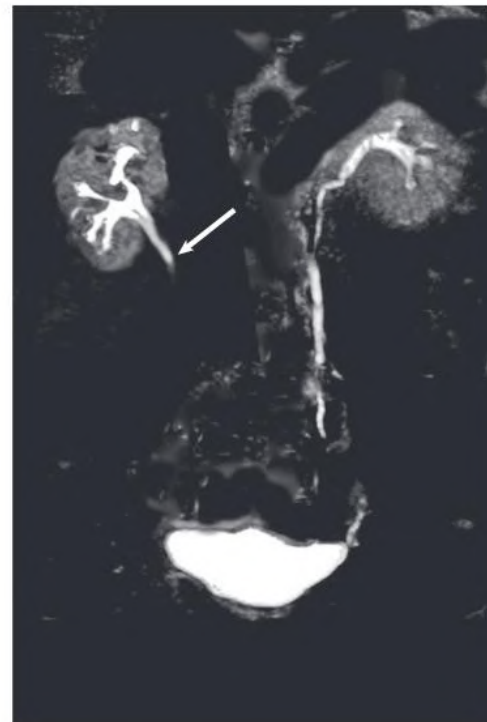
Magnetic Resonance (MR) Urography Showing Obstructive Uropathy. T2-weighted MR image showing a proximal right-sided ureteric obstruction with an associated mild hydronephrosis. The obstruction was secondary to a ureteral calculus.
